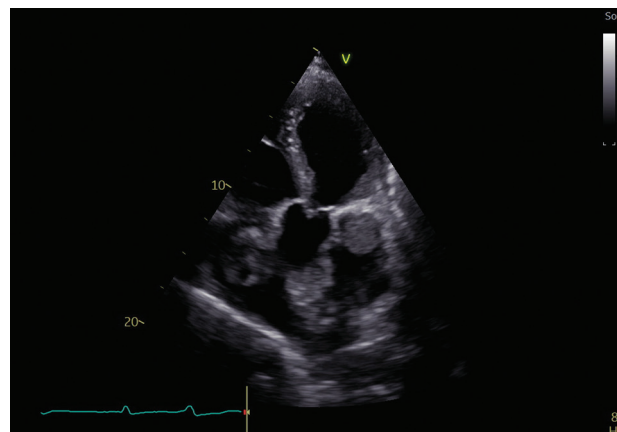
Transthoracic echocardiography image showing right and left atrial masses with different structures.
